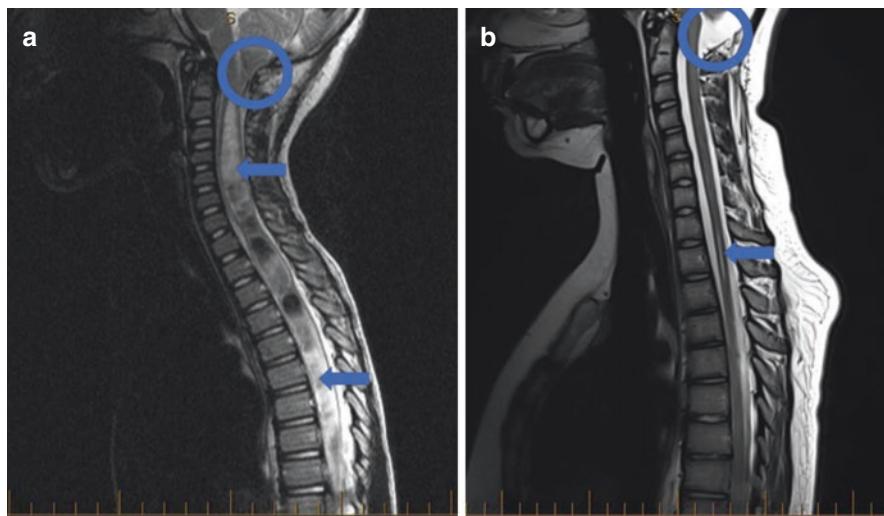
(a) A 4 yo with early-onset thoracic scoliosis measuring 30 degrees. An asymmetric abdominal reflex was also noted. MRI showed a Chiari type 1 malformation (*circle*) and large syringomyelia extending the length of her cervical and thoracic spine (*arrows*). She underwent decompression of the Chiari malformation. (b) MRI at age 15 years showed resolution of the Chiari lesion (*circle*) and with only a small residual syringomyelia (*arrow*). Her scoliosis remained stable and never needed surgical treatment
